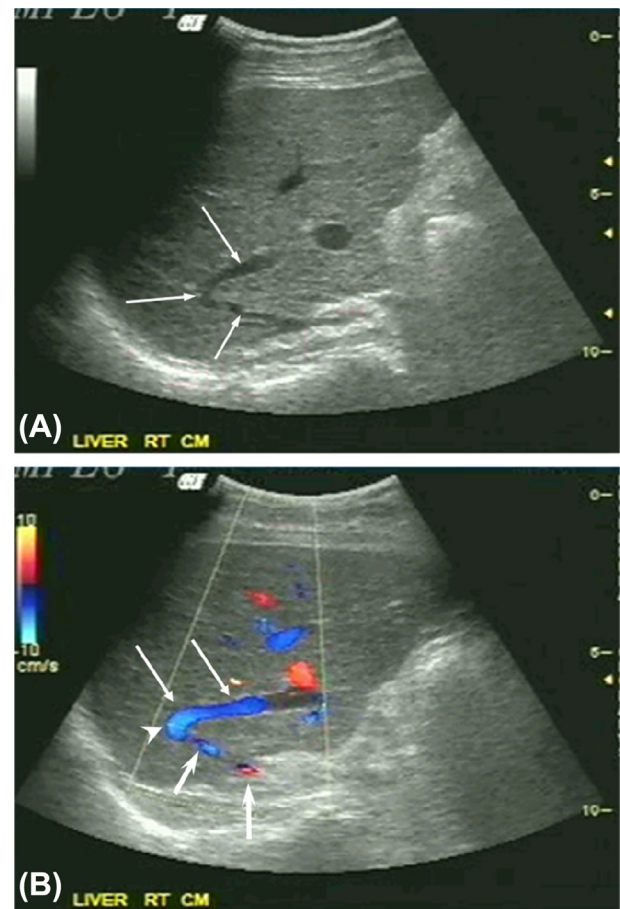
Gray-scale and color Doppler US studies of the liver. (A) Gray-scale US of the right hepatic lobe (intercostal scan) demonstrates a venous structure which is suspected to run in a curved course (arrows), and connection between a portal branch and a hepatic vein is possible; (B) color Doppler US depicts a possible communication (arrowhead) between a branch of the right portal vein (small arrows) and the right hepatic vein (large arrows). However, the continuity of the vessels cannot be well portrayed. US = ultrasound.
